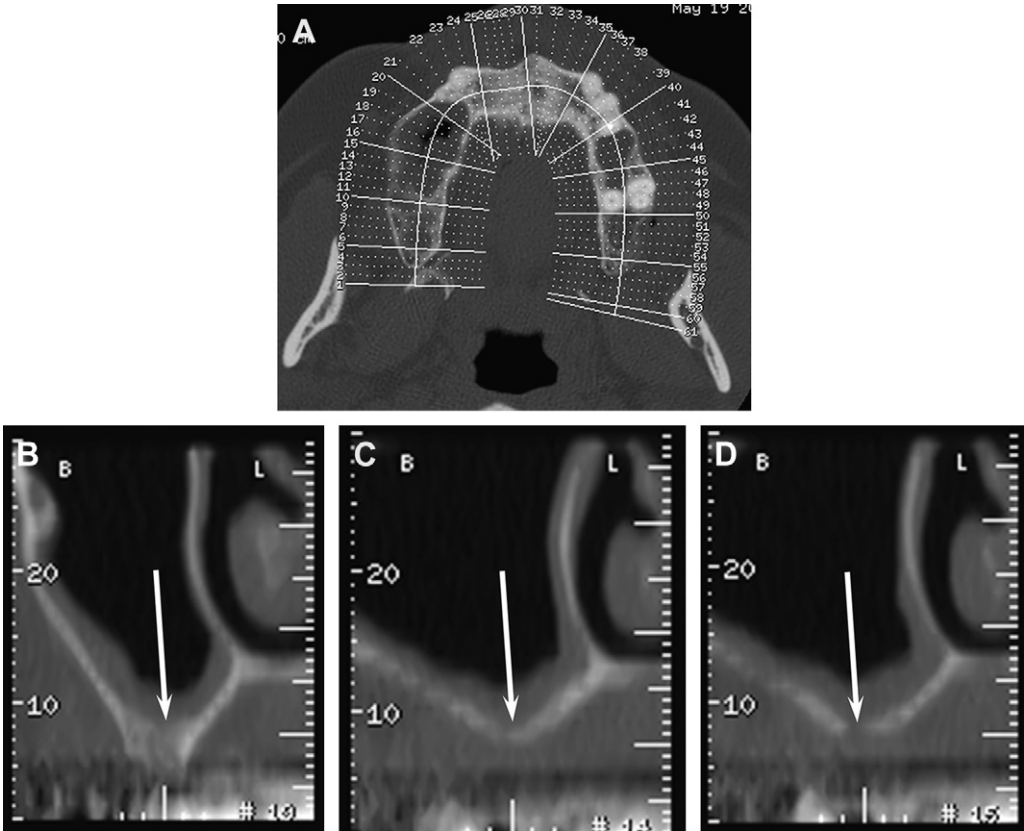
Utility of CT postprocessing for evaluating the alveolus. (A) Scout axial CT image delineates the angles of the reconstructed sagittal oblique images designed to be perpendicular to the alveolar ridge. Each image is numbered so that the exact location can be referenced. The resulting reformatted images show normal thickness of the alveolar ridge (*arrow* in B), thinning of the ridge (*arrow* in C), or breakthrough into the maxillary sinus (*arrow* in D).
